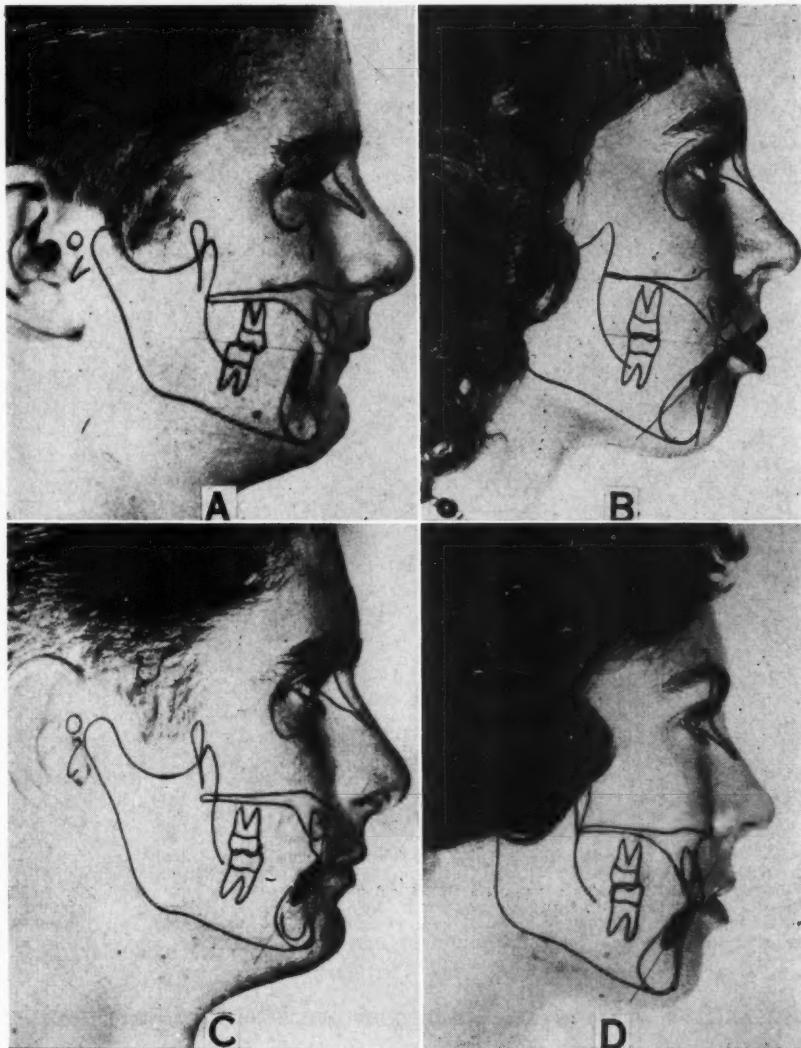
Tracings of cephalometric roentgenograms superimposed over photographs. *A*, Severe Class II in malocclusion well-developed boy (Robert). Note mandibular arch retraction and sublabial tension in the mouth (lower incisor is -7 mm. from the A-Pog plane). *B*, Severely crowded and prognathic Class I malocclusion in Ann (lower incisor inclined forward and located +8 mm. to the A-Pog plane). *C*, Robert's tracings after treatment. Note that the position of the lower incisor is now almost on the A-Pog plane. Compare with treatment plan shown in Fig. 2. *D*, Ann's tracings after treatment. The lower incisor was retracted almost to the A-Pog plane.
